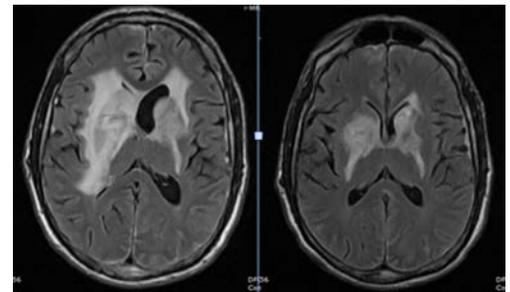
T2-FLAIR axial view MRI on left shows marked progression of signal abnormalities in deep parenchyma, compared with more subtle changes noted 3 months prior, pictured on right.
